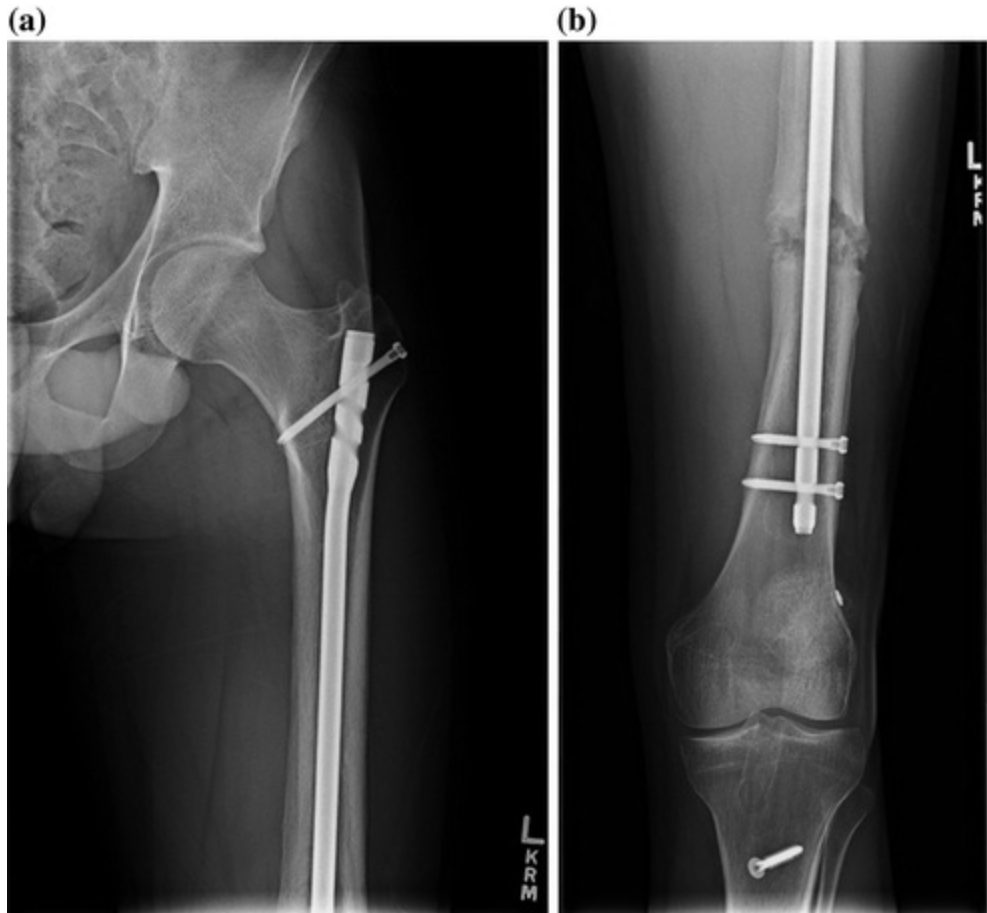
Initial femur postoperative X-ray s at 3 months with nonunion (a, b)
